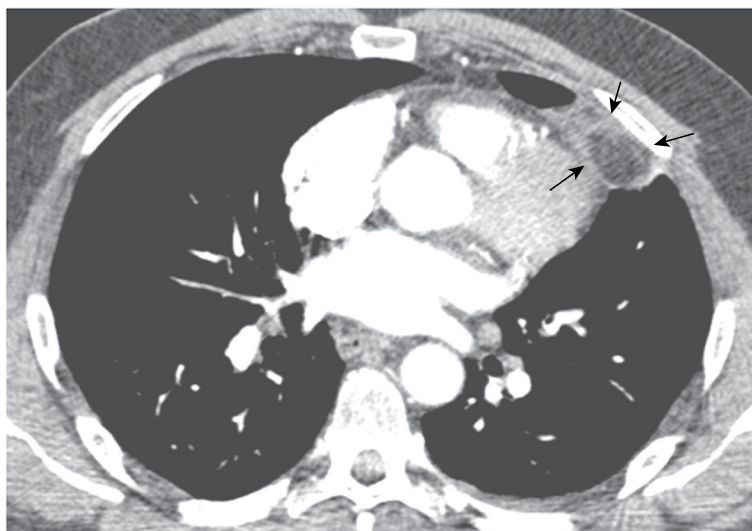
Contrast-enhanced CT image (soft-tissue window) showing an ovoid mediastinal fatty lesion (arrowheads) in the left cardiophrenic region, demarcated by a soft-tissue attenuation ring.
